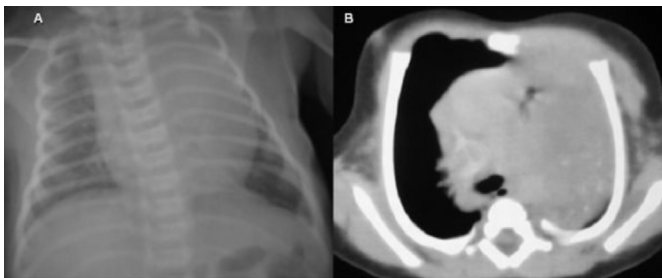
(a) Postero-anterior chest radiography reveals relatively well demarcated opaque appearance which cannot be clear separation from surrounding and compresses mediastinum located in the left upper pulmonary zone. (b) Well demarcated hypodense lesion that fills left upper lobe of the lung is present in CT imaging of thoracic cage. Punctuate calcification on posterior side of the lesion.
